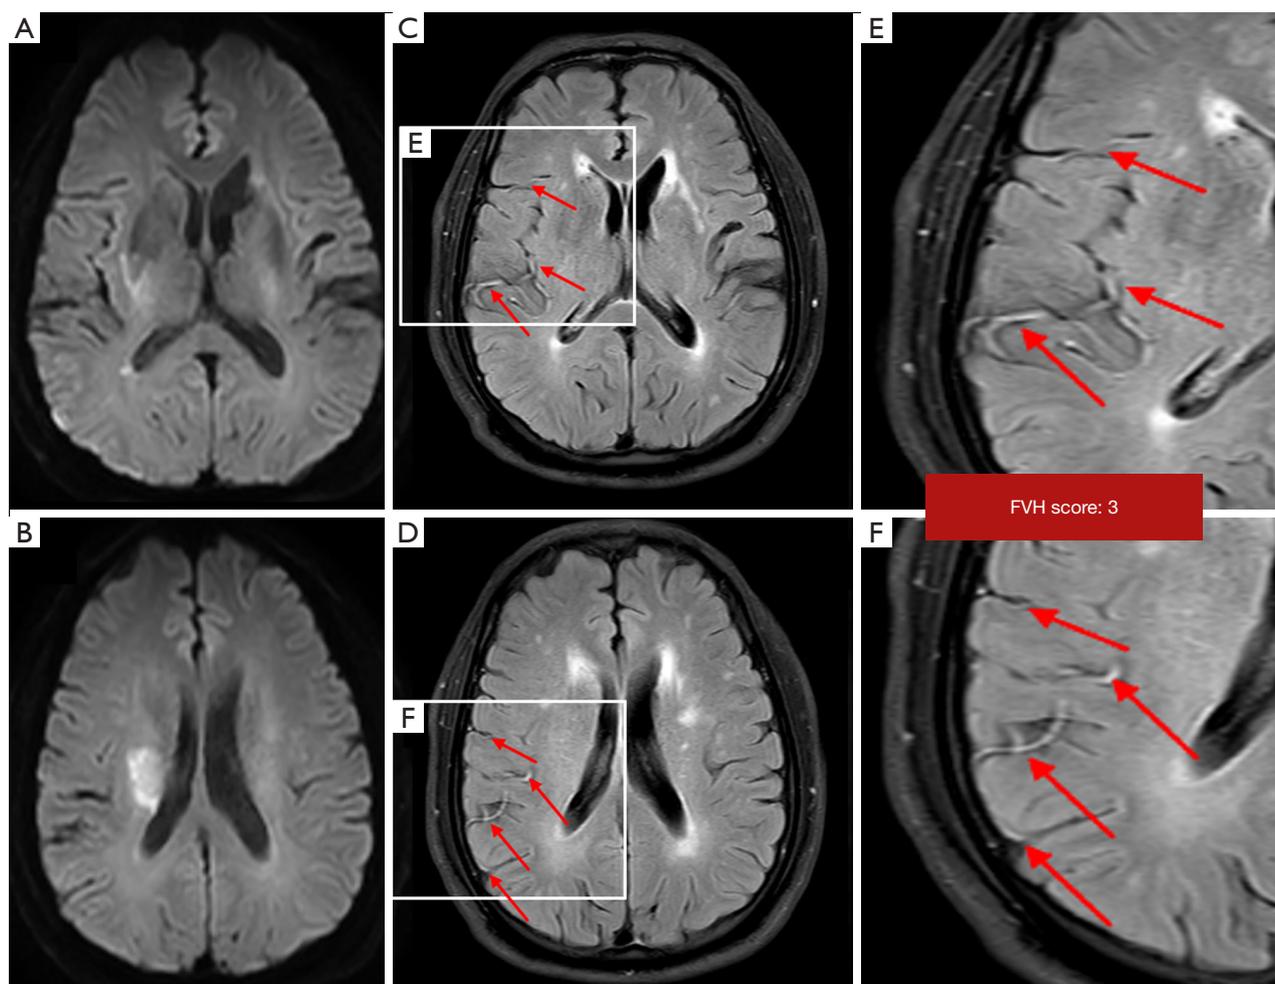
An fluid-attenuated inversion recovery vascular hyperintensity (FVH)-diffusion-weighted imaging (DWI) mismatch case. (A,B) DWI and (C,D,E,F) fluid-attenuated inversion recovery (FLAIR) images. Some FVH (red arrow) was observed beyond the boundaries of the DWI lesion. The patient was classified as FVH-DWI mismatch. FVH was found in the M2, M5, and M6, so the FVH score was 3.
